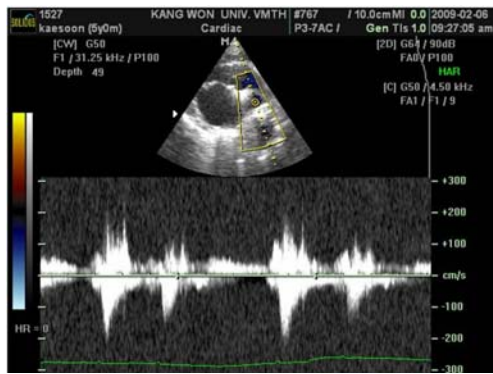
Color Doppler echocardiography taken after the occlusion using a ductal occluder. There was a minimal residual shunt flow between dAo and pulmonary artery because of the reverse positioning of the occluder.
